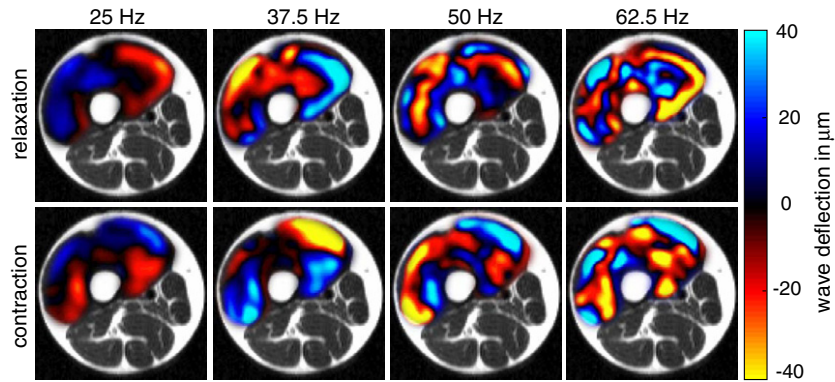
Experimental MRE waves $Re(U[x, y, \omega])$ (color coded) superimposed on T2-weighted MRI (field of view: 150 mm \times 150 mm) in a transversal image plane of the thigh of a volunteer. Top and bottom rows display experiments in relaxation and with maximum voluntary contraction, respectively.
